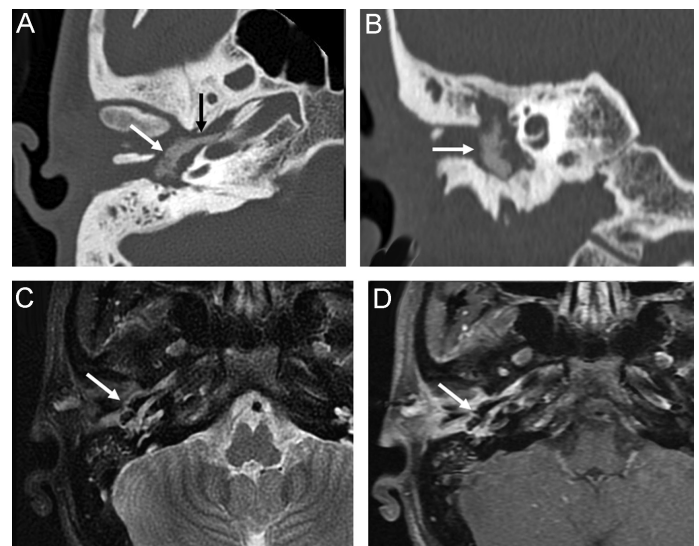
(A) Axial and (B) coronal computed tomography images with bone algorithm show a hyperdense foreign body occupying the right middle ear cavity (white arrows) and extending to the eustachian tube (black arrow in A). Bone erosion is present with the destruction of the ossicles. (C) Axial T2 weighted image with fat suppression shows the foreign body within the middle ear cavity to have low T2 signal intensity (arrow). (D) Axial contrast-enhanced T1 weighted image with fat suppression shows a lack of enhancement in the foreign body (arrow) with surrounding significant enhancement.
